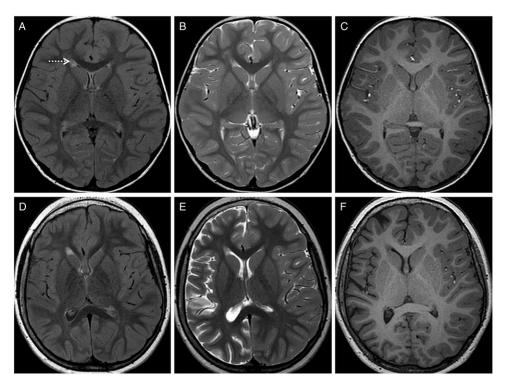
Evolution of Rasmussen encephalitis. Axial FLAIR (A) and axial T2-weighted (B) sequences reveal a small nonspecific focus of hyperintensity in the right frontal lobe (dotted arrows). Axial 3D-T1 sequence (C) shows normal volume of the right cerebral hemisphere. Follow-up MRI (D-F) obtained after 3 years due to medically refractory focal epilepsy, occurring multiple times daily, and emerging left hemiparesis. Axial FLAIR (D), axial T2-weighted (E), and axial 3D-T1 (F) sequences reveal marked volume loss of the right cerebral hemisphere, seen in the form of ex-vacuo dilation of the right lateral ventricle and prominence of the sulcal spaces. Note, apart from non-specific FLAIR/T2 hyperintensity along the right frontal horn, there is no other signal abnormality seen in the rest of the brain parenchyma.
